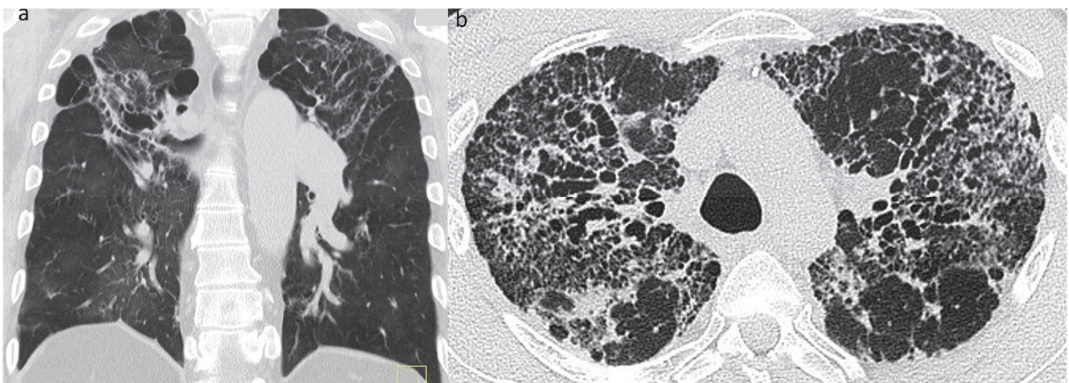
(a,b) Bilateral upper zone fibrosis with volume loss in two patients with sarcoidosis: (a) striking peri-bronchovascular fibrosis with retractile airway dilatation (i.e., traction bronchiectasis) and (b) CT through the upper lobes in a 64-yr-old male patient. Again, note the marked bronchocentric reticulation with severe traction bronchiectasis, which is particularly severe on the right.
